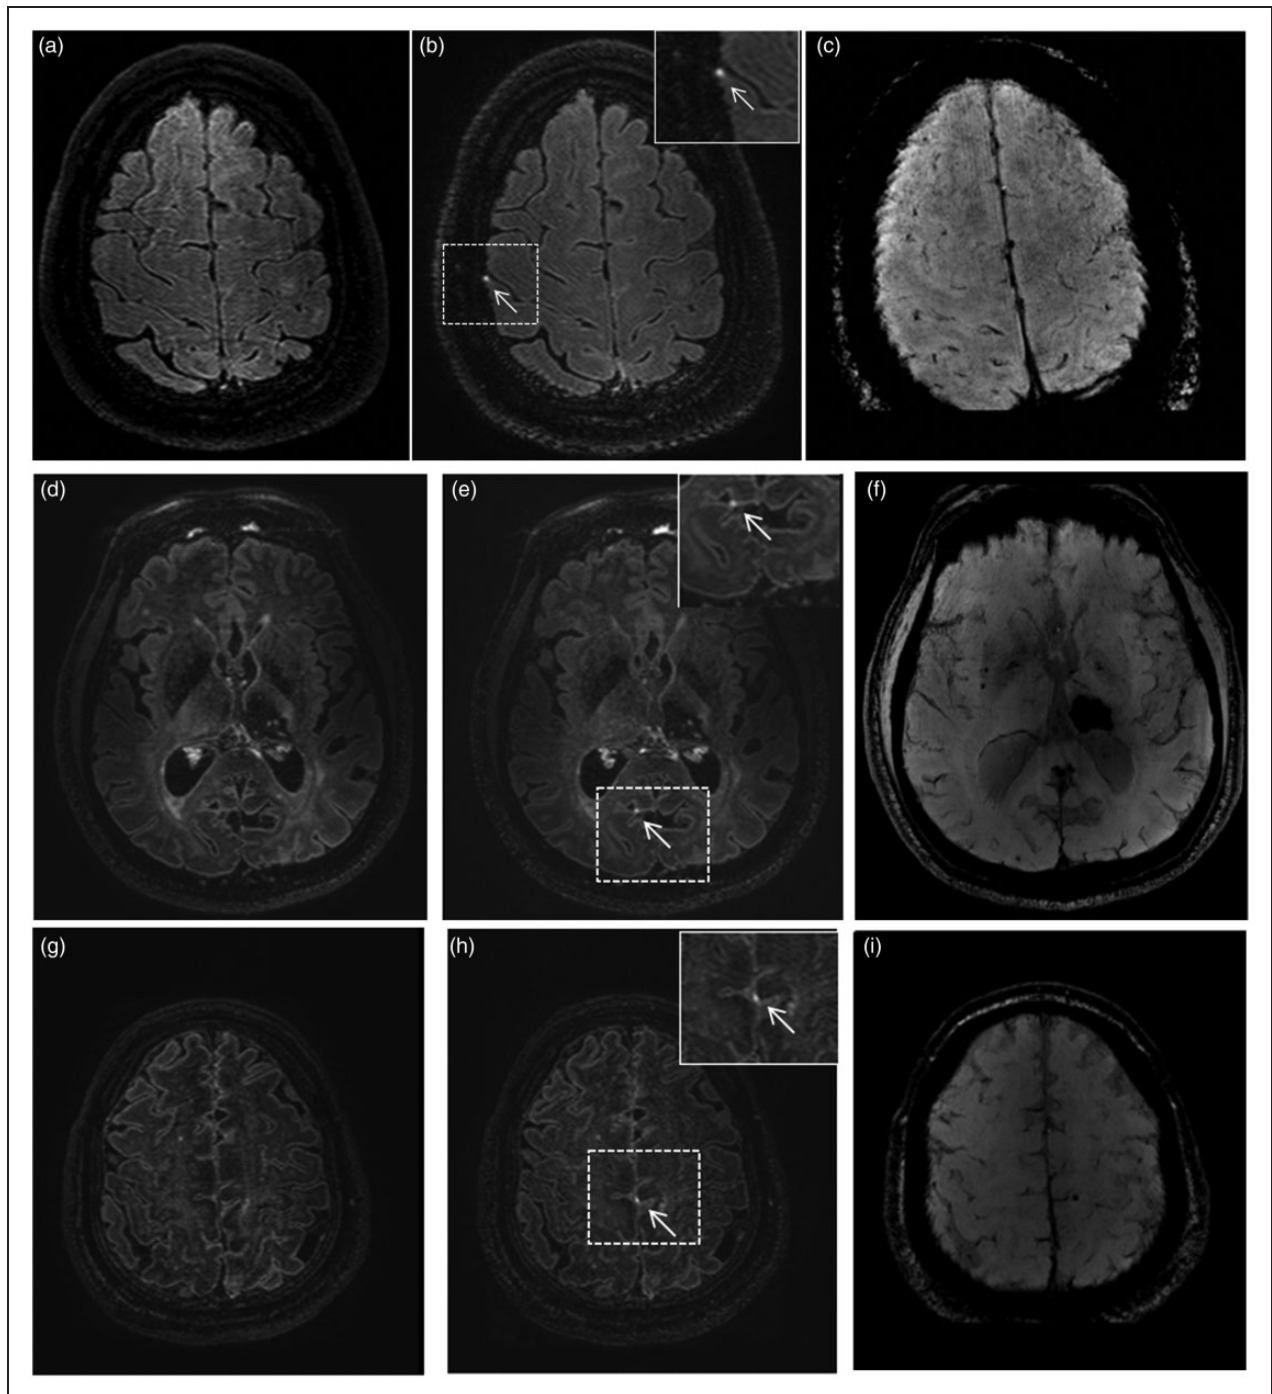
Examples of patients with different HARM scale scores. HARM 1: Punctate lesion of contrast leakage. Pre- (panel A) and postgadolinium (panel B) FLAIR images of a 41-year-old man with an infratentorial hemorrhage, a right frontal punctate lesions (white arrow) of contrast leakage and no abnormalities at that site on SWI (panel C). HARM 2: Multiple punctate lesions of contrast leakage. Pre- (panels D and E) and postgadolinium (panels G and H) FLAIR images of a 54-year-old man with left deep ICH, right occipital (white arrow) and left frontal lesions (white open arrow) of contrast leakage and no abnormalities at those sites on SWI (panel F and I). HARM 3: Focal sulcal contrast leakage. Pre- (panel J) and postgadolinium (panel K) FLAIR images of a 45-year-old man with a left deep ICH, left parietal focal sulcal contrast leakage (white arrow) and no abnormalities at that site on SWI (panel L). HARM 4: Bilateral and diffuse contrast leakage. Pre- (panel M) and postgadolinium (panel N) FLAIR images of a 67-year-old woman with right deep ICH, extensive bilateral and generalized occipital contrast enhancement (white arrows) and multiple cerebral microbleeds at that site on SWI (panel O).
